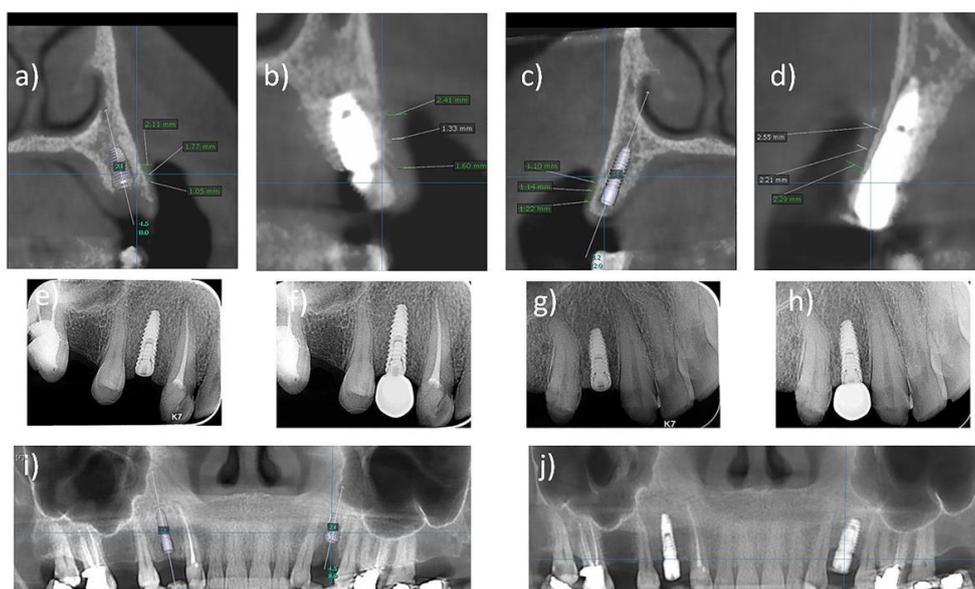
Pre and post-operative radiographic assessment. a) preoperative CBCT image showing: Cross-sectional view for the missed upper left first premolar with the thickness of facial gingiva at T0, b) post-operative CBCT image showing: Cross-sectional view for the left implant placed at T1, c) preoperative CBCT image showing: Cross-sectional view for the missed upper right first premolar with the thickness of facial gingiva at T0, d) post-operative CBCT image showing: Cross-sectional view for the right implant placed at T1, e) Periapical radiograph taken immediately after implants placement at the right side at T0, f) Periapical radiograph taken immediately after prosthesis placement at the right side at T1, g) Periapical radiograph taken immediately after implants placement at the left side at T0, h) Periapical radiograph taken immediately after prosthesis placement at the left side at T1, i) preoperative CBCT image showing: Panoramic view for the missed upper left and right first premolars with the virtual implant placement at T0, j) Panoramic radiograph taken at the beginning of the prosthetic phase T1.
